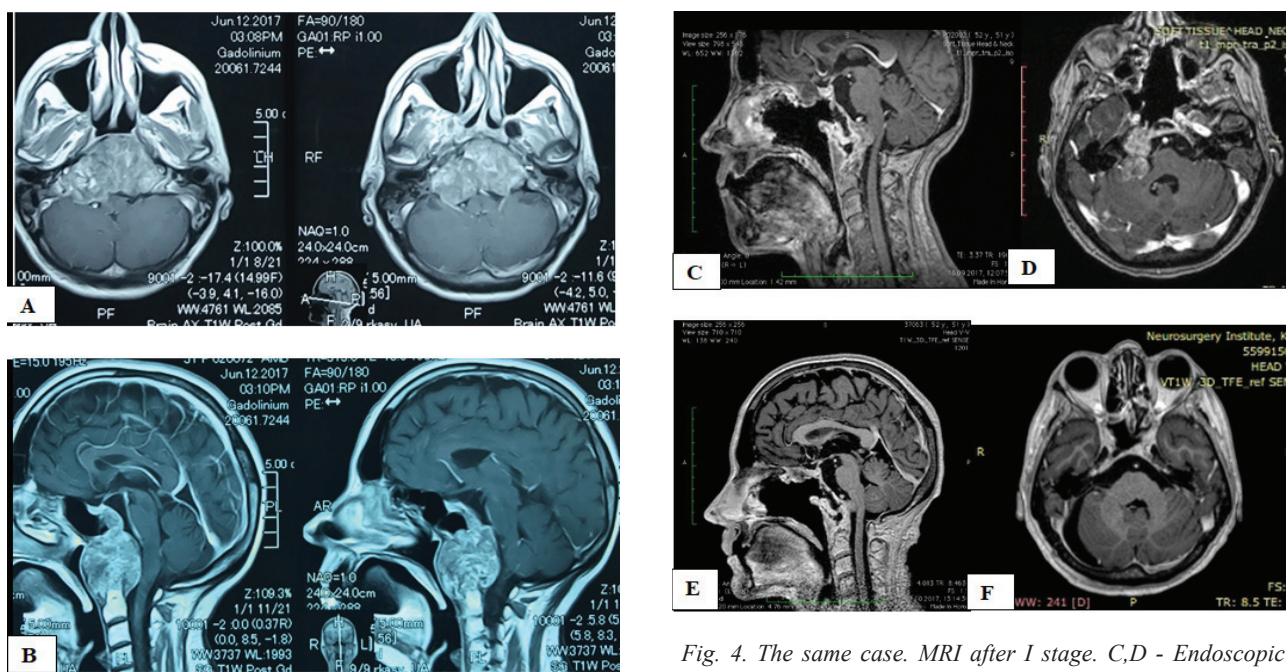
Clival chordoma, 60x48x42 mm (A, B - MRI preop)
